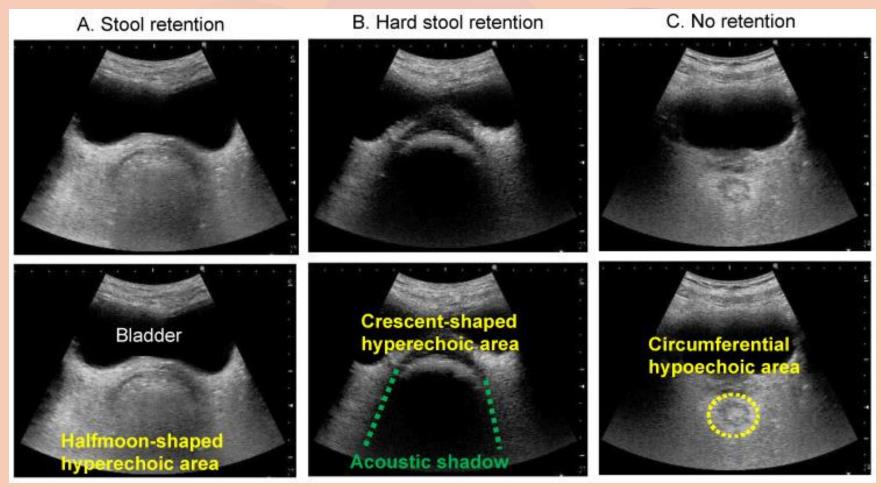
Utility of gastrointestinal ultrasound in functional gastrointestinal disorders: A narrative review
